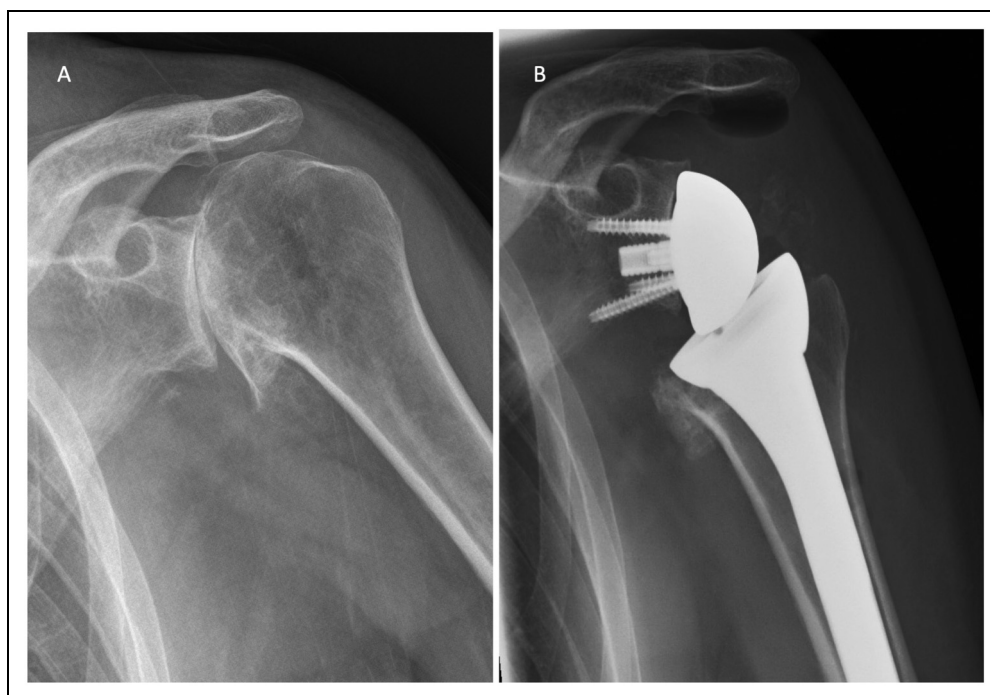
A. Preoperative left shoulder anteroposterior radiograph showing prominent inferior osteophyte and end-stage osteoarthritis. B. Postoperative left shoulder anteroposterior radiograph showing Delta Xtend™ reverse shoulder system (De Puy Synthes), inferior osteophyte can still be noticed.
